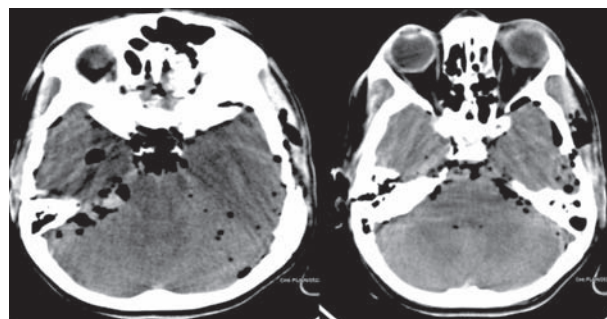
CT scan of brain 3 hrs following trauma shows diffuse pneumocephalus and subarachnoid hemorrhage in the right CP angle cistern.
